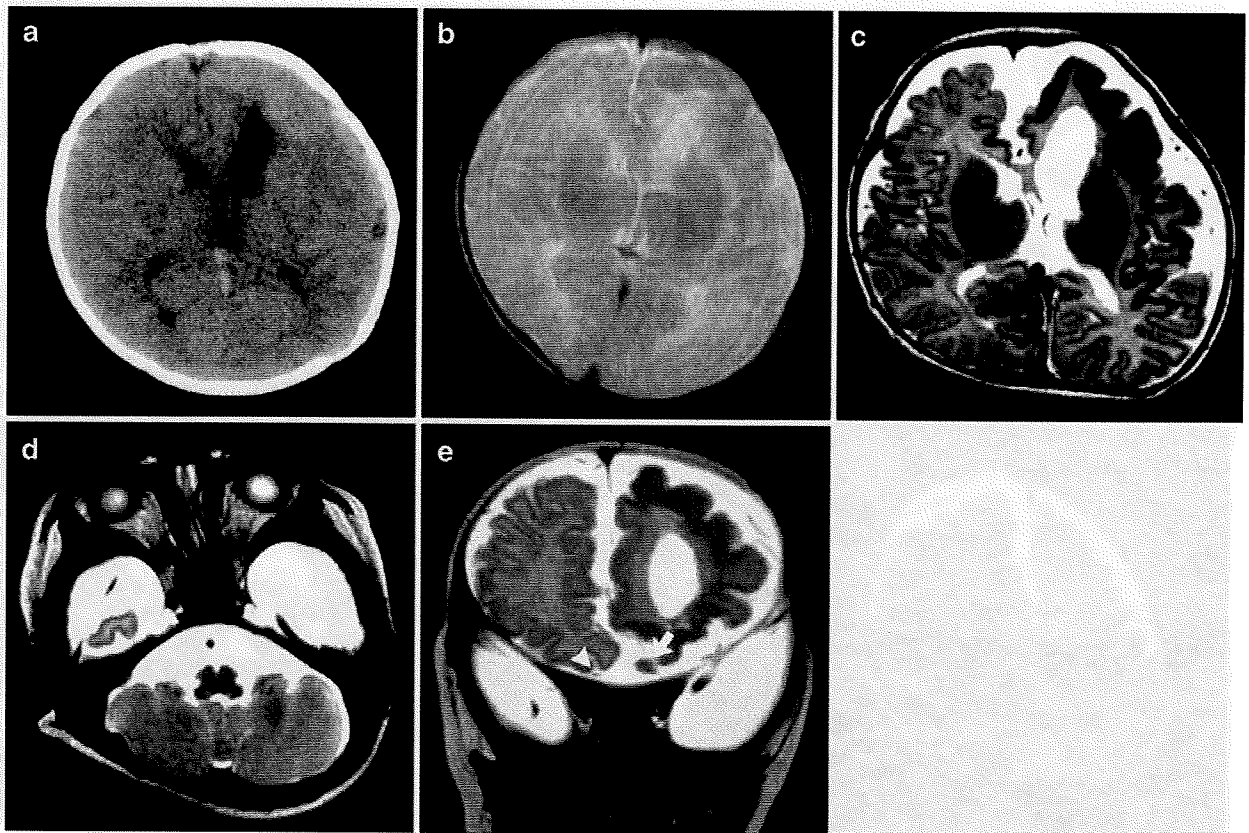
Computer tomography (CT) and follow-up MR images of a boy with left localized megalencephaly in whom seizures commenced at 2 days of age and continued at a frequency of approximately ten per day (grade 2). a, b At 4 weeks of age, CT and axial T2-weighted images show focally enlarged frontal and temporal lobes in the left hemisphere (frontal-lobe-dominant type). c At 11 weeks of age, the axial T2-weighted image shows that his affected frontal area has turned atrophic. The left lateral ventricle is enlarged. The left
